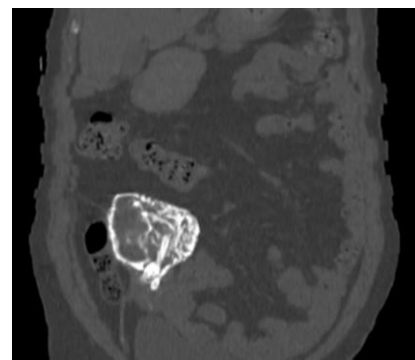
Plain CT coronal section reveals: a well-defined calcified ovoid lesion, suggestive of a mummified fetus with detailed anatomy.
